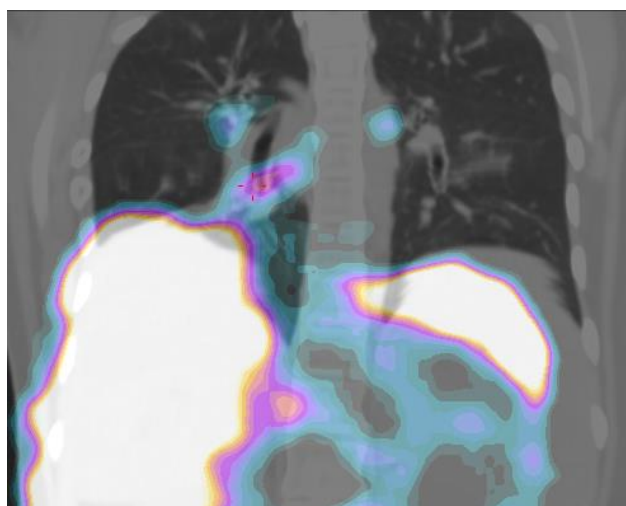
99mTc-mebrofenin SPECT/CT is identified area of pathological uptake of the radiopharmaceutical arising from the liver dome and extending to the inferior bronchus of the right lung.
